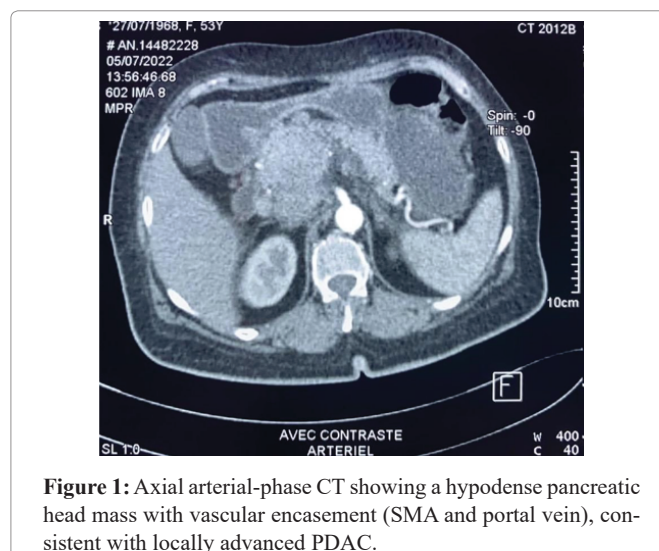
Axial arterial-phase CT showing a hypodense pancreatic head mass with vascular encasement (SMA and portal vein), consistent with locally advanced PDAC.
